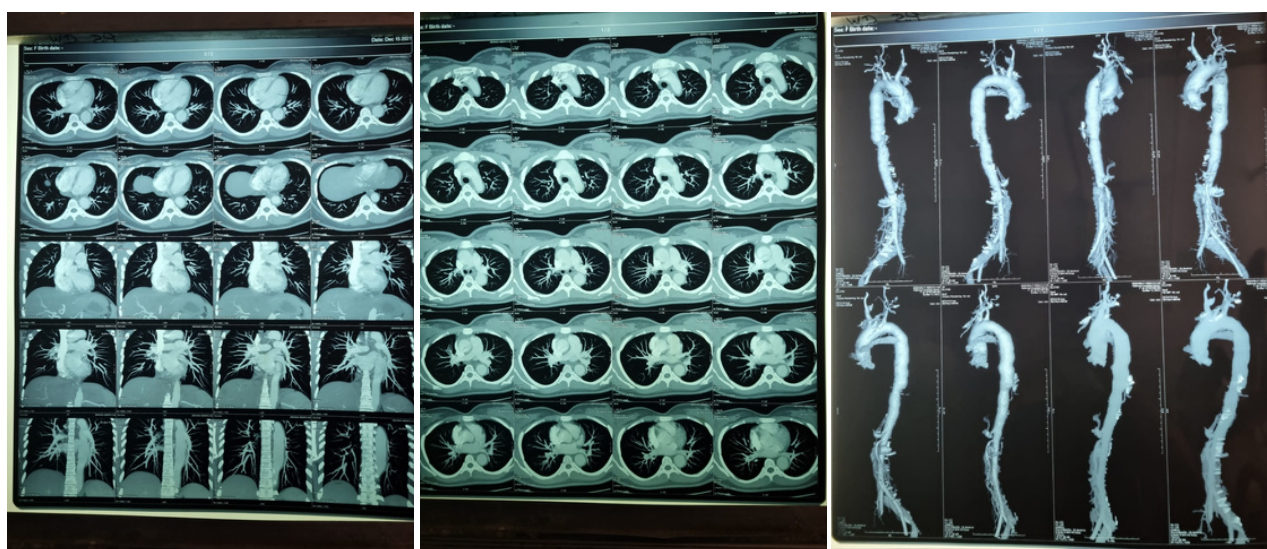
CT angiogram of the thoracic and abdominal aorta showing diffuse thickening of ascending and descending aorta, arch of aorta, carotid arteries, coeliac axis, superior mesenteric artery, and renal arteries, suggestive of acute active phase of Type iii TA.
